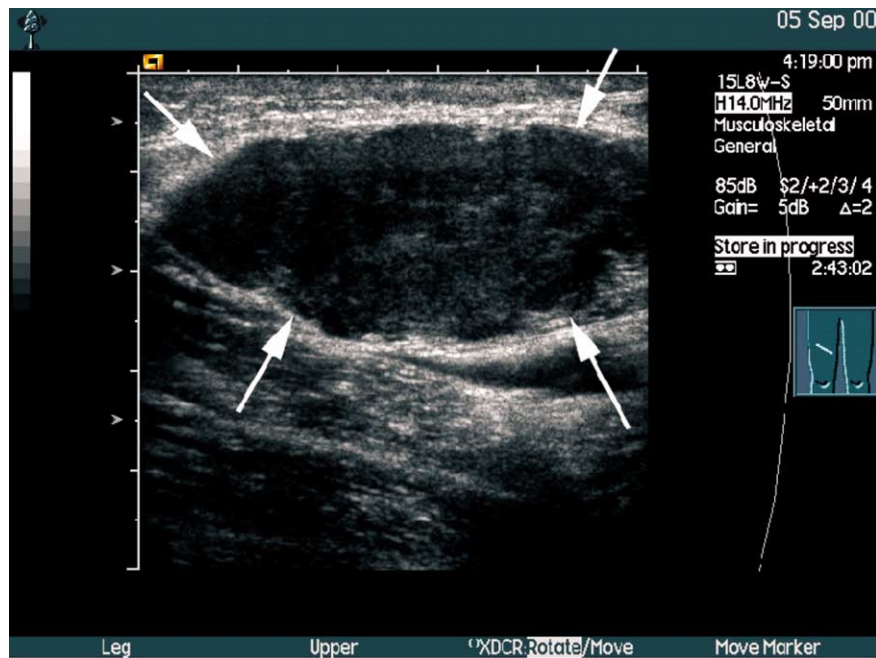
Grey-scale ultrasound image of a leg sarcoma, indicated by arrows.
